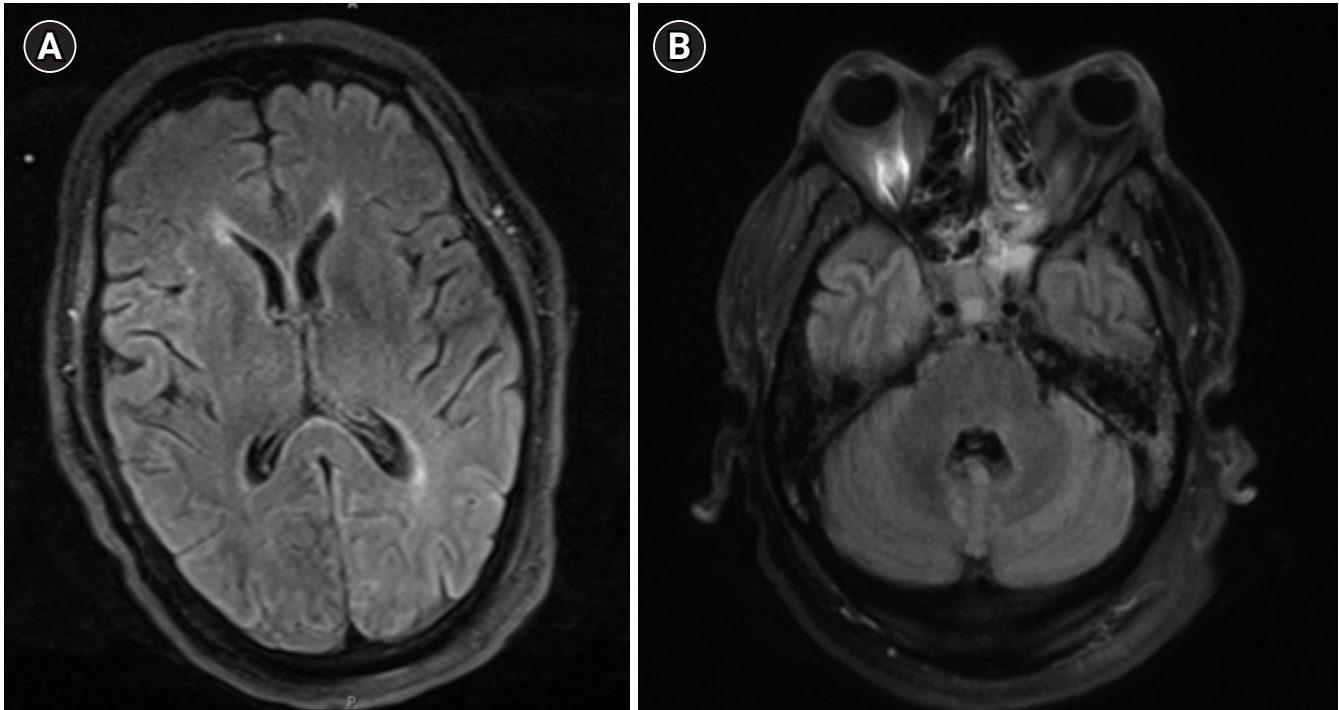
(A, B) Brain magnetic resonance imaging taken 12 days after fever resolution did not demonstrate cortical or metabolic injury.
